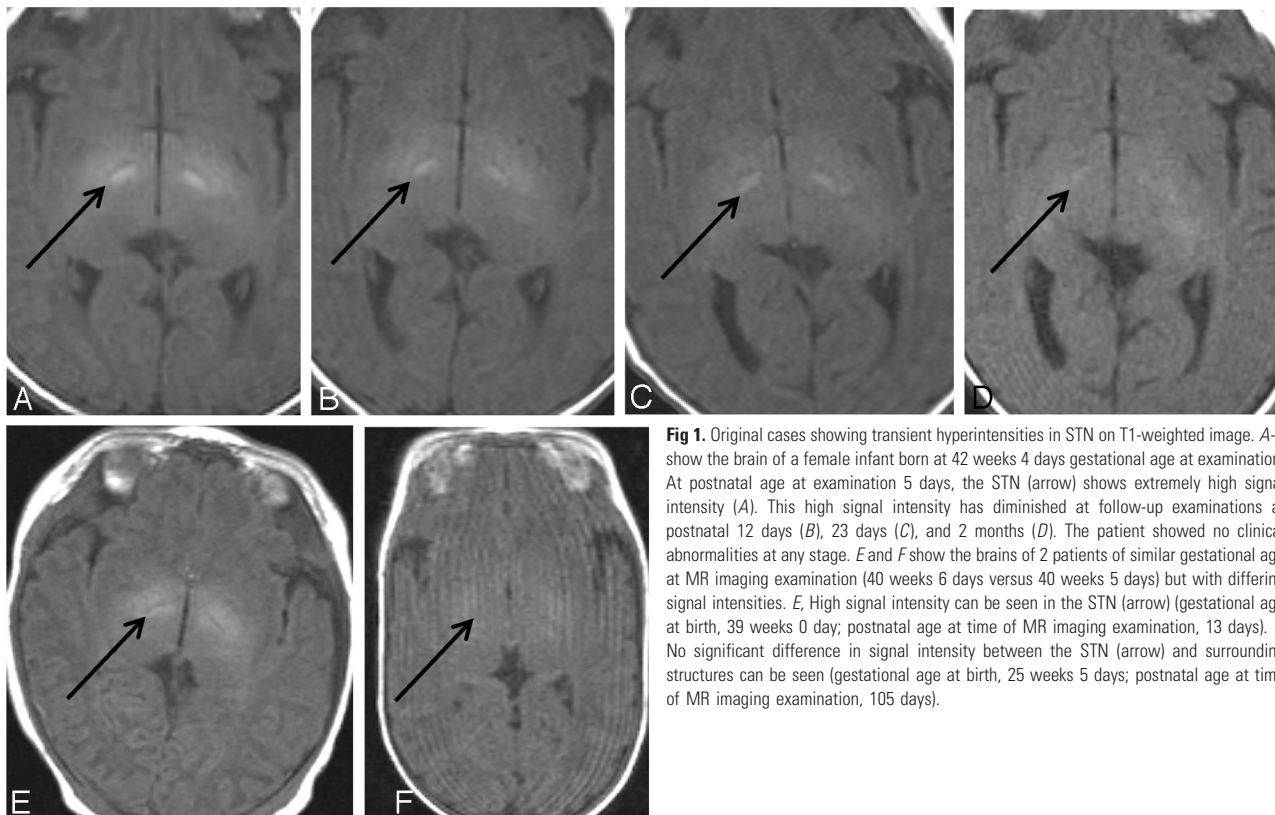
Original cases showing transient hyperintensities in STN on T1-weighted image. *A-D* show the brain of a female infant born at 42 weeks 4 days gestational age at examination. At postnatal age at examination 5 days, the STN (arrow) shows extremely high signal intensity (*A*). This high signal intensity has diminished at follow-up examinations at postnatal 12 days (*B*), 23 days (*C*), and 2 months (*D*). The patient showed no clinical abnormalities at any stage. *E* and *F* show the brains of 2 patients of similar gestational age at MR imaging examination (40 weeks 6 days versus 40 weeks 5 days) but with differing signal intensities. *E*, High signal intensity can be seen in the STN (arrow) (gestational age at birth, 39 weeks 0 day; postnatal age at time of MR imaging examination, 13 days). *F*, No significant difference in signal intensity between the STN (arrow) and surrounding structures can be seen (gestational age at birth, 25 weeks 5 days; postnatal age at time of MR imaging examination, 105 days).
